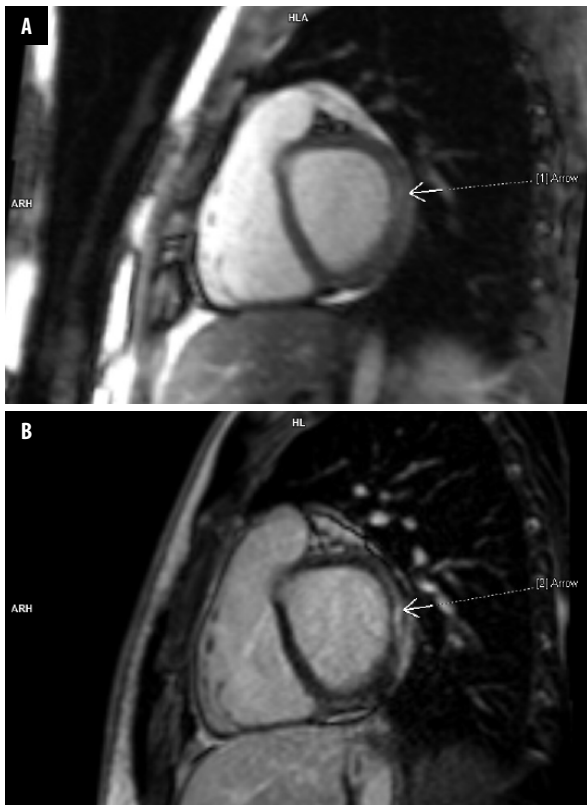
A, B. Cardiac magnetic resonance imaging, T2-weighted image (A) and late contrast enhancement image (B) revealing subepicardial area of oedema (A) corresponding to late contrast enhancement (B)
